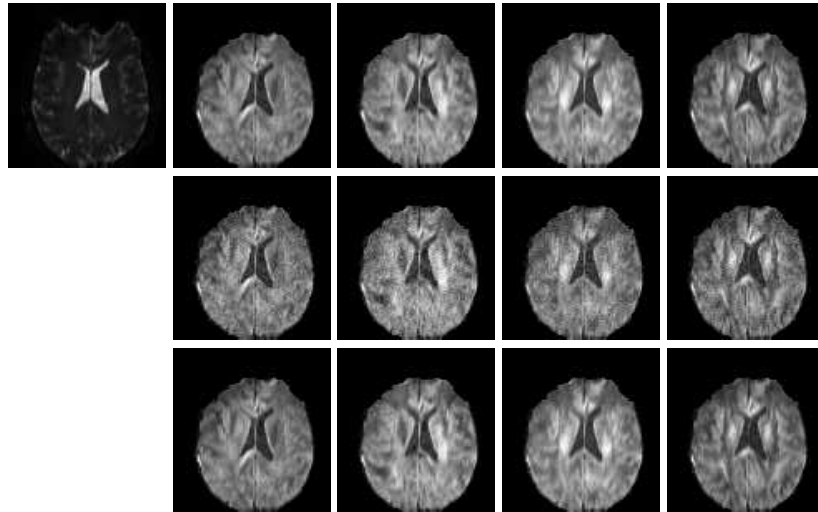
Denoising experiment of real MRI data. Top: left, S_0 ; right, original clean slices. 2nd row: noisy slices (artificial Rician noise). 3rd row: denoised slices. $M(\text{original}, \text{noisy}) = 2.8350$, $M(\text{original}, \text{denoised}) = 1.1564$. $\text{rmse}(\text{original}, \text{noisy}) = 10.5448$, $\text{rmse}(\text{original}, \text{denoised}) = 4.7268$.
